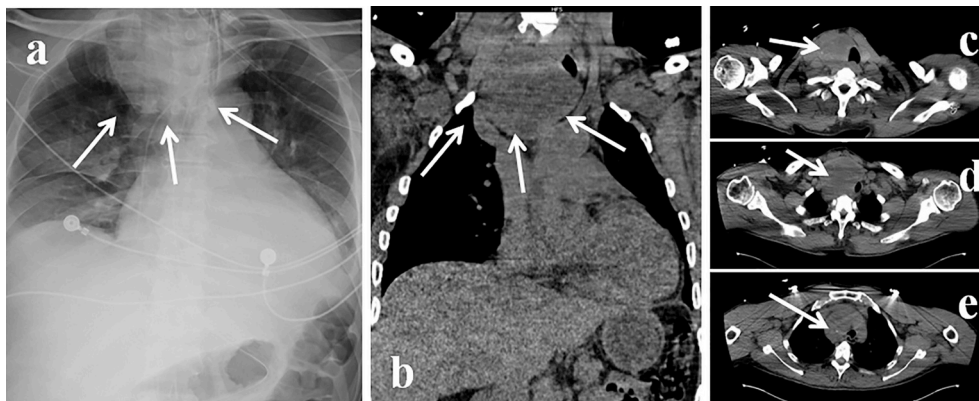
a/Chest x-ray showing large neck mass (arrows) b/CT-scan at admission (sagittal): large retrosternal goiter reaching level of the aortic arch (arrows). c,d,e/CT-scan at admission (transverse cuts at various levels): large goiter compressing trachea and displacing it to the left (arrow).
